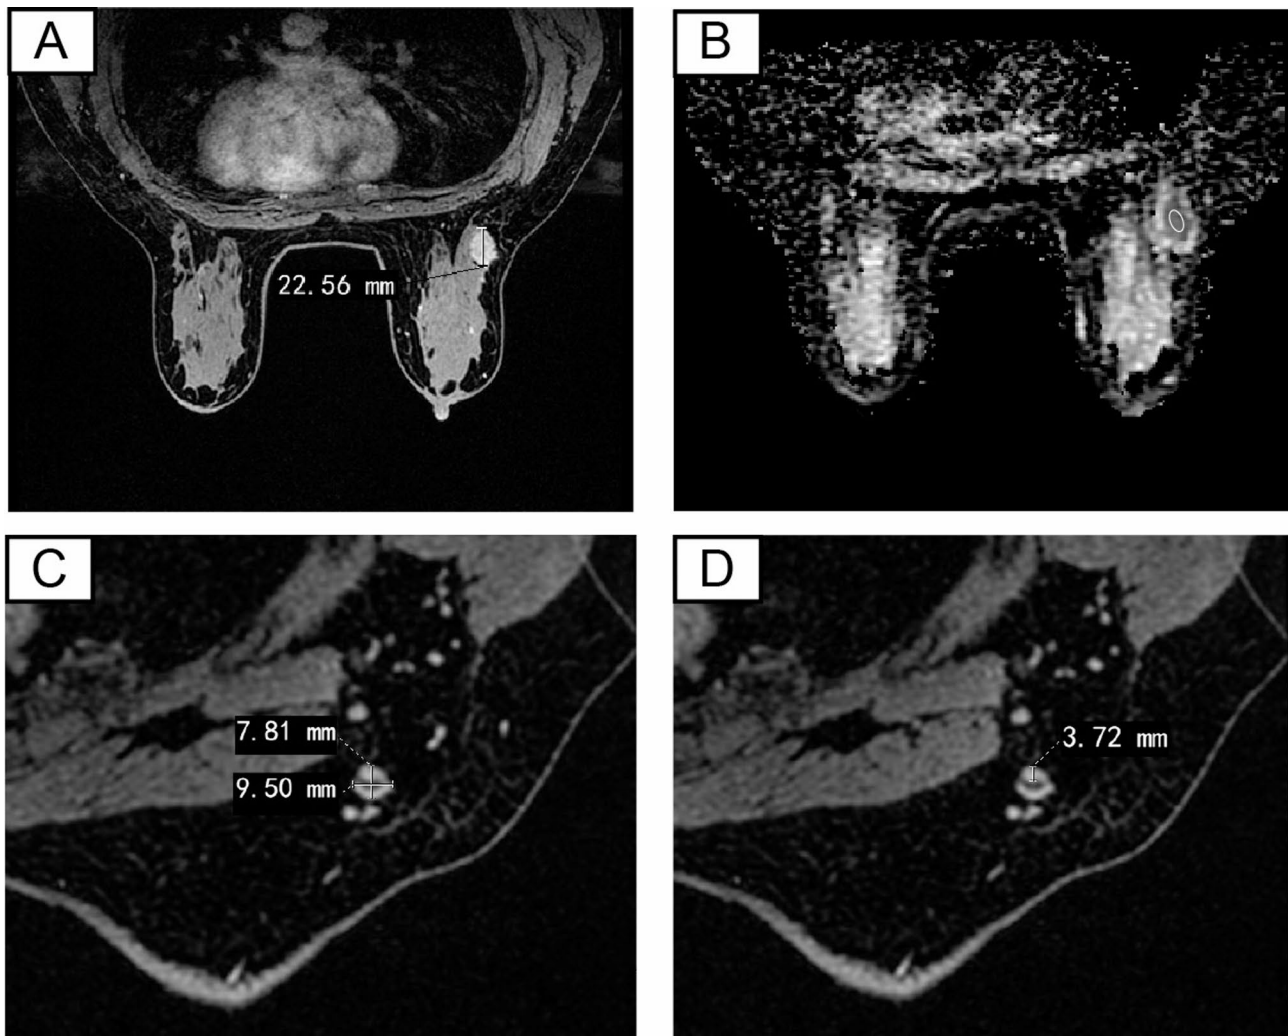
Methods of measuring tumor and the most suspicious level I axillary lymph node status on MRI. A The maximum diameter as tumor size. B The ADC value of the tumor was derived from the average of three measurements taken by the radiologist at different locations of the ROIs. C The maximum long diameter and the maximum short diameter of the target lymph node. D The maximum cortical thickness of the target lymph node. ADC, apparent diffusion coefficient; ROIs, region of interests
